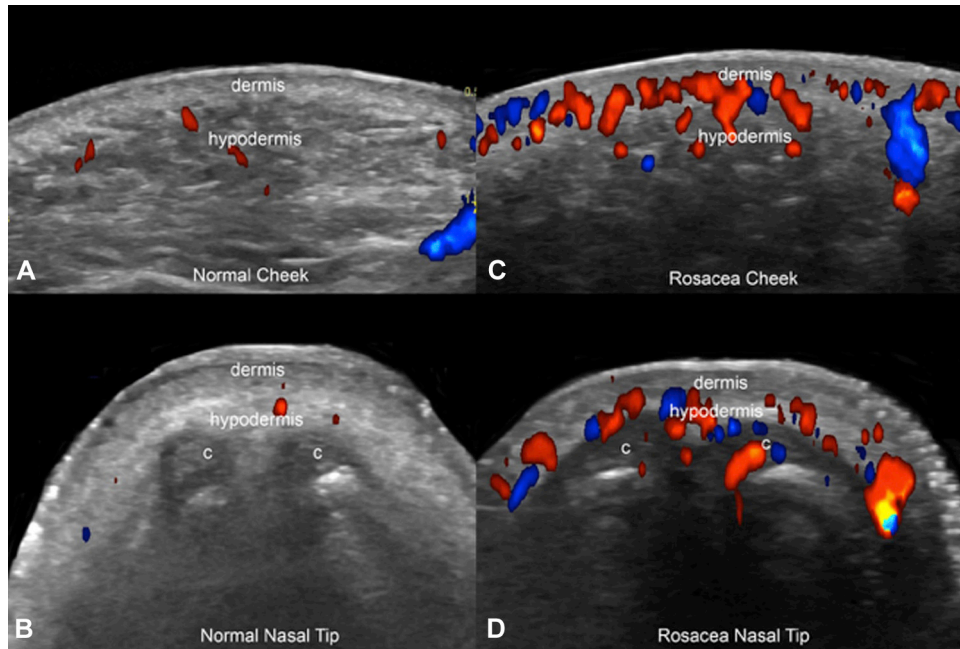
Color Doppler ultrasonographic comparative views of (A, B) healthy control individuals and (C, D) patients with rosacea at the (A, C) right cheek and (B, D) nasal tip (transverse views). Notice the dermal and hypodermal hypervascularity at the cheek in the rosacea. There is also increased dermal and hypodermal vascularity as well as hypervascularity of the alar cartilage at the nasal tip in rosacea. c, Alar cartilage.
